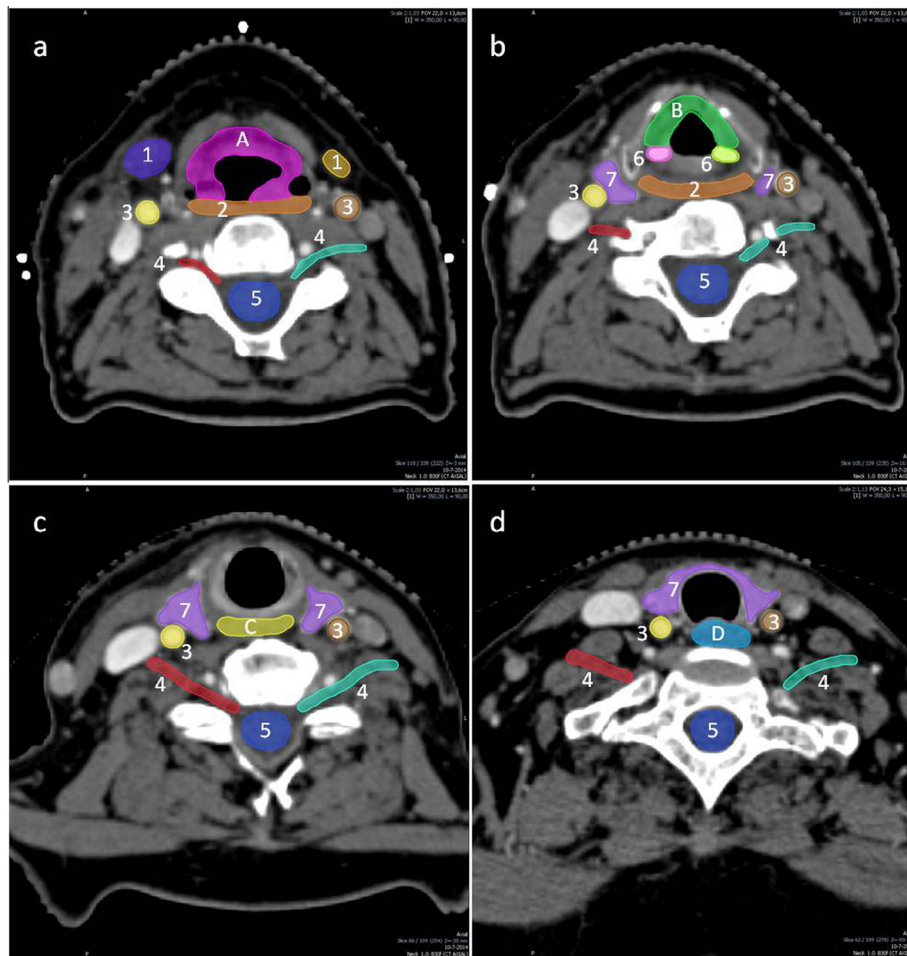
Axial CT slices showing the delineation of the supraglottic larynx (A) (a), glottic area (B) (b), crico-pharyngeal inlet muscle (C) (c), and cervical esophagus (D) (d). Other organs at risks visible are the submandibular glands (1), pharyngeal constrictor muscles (2), carotid arteries (3), brachial plexus (4), spinal cord (5), arytenoids (6) and thyroid (7). (For the full atlas, the reader is referred to the [Supplemental material](#).)
